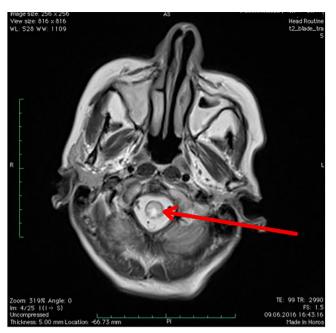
MR of the brain and the spinal cord of a female age 62, diagnosed with NMOSD: T2-weighted images – hyperintensive inflammatory lesion in the brain (transverse view)
